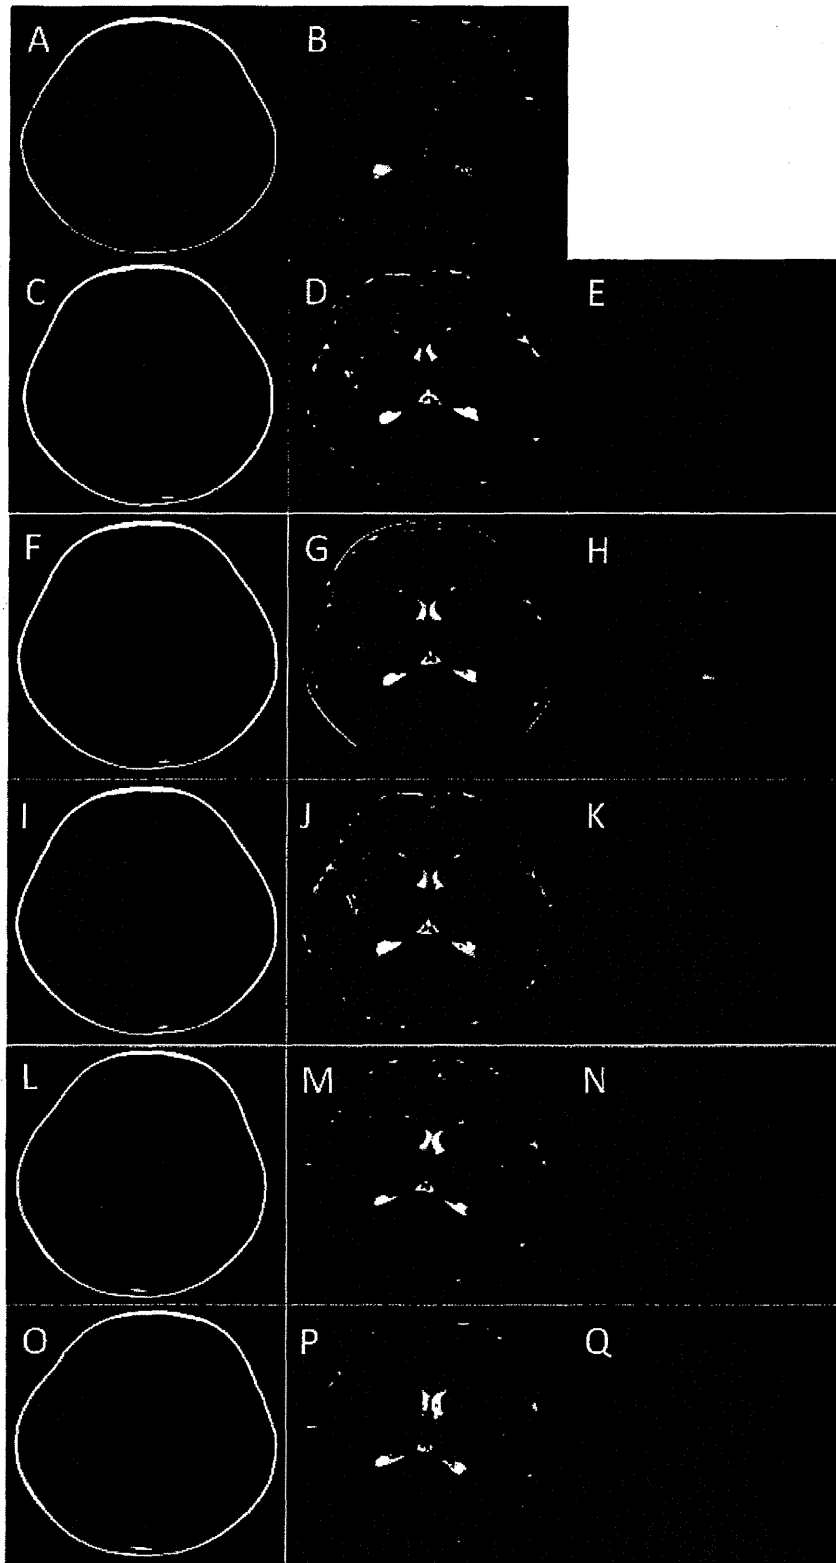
Magnetic resonance images of the first episode (A, B: on admission; C–E: 2 months after the admission), the second episode (F–H: on admission; I–K: on the 8th hospital day), and the third episode (L–N: on admission; O–Q: on the 6th hospital day). Diffusion-weighted image in the first episode on admission was not performed. Hyperintense signal in the splenial lesion of the corpus callosum (SCC) on T2-weighted image in the first episode (B), on T2-weighted and diffusion-weighted images in the second episode (G, H), and in the third episode (M, N) completely disappeared at 2 months after (D), 7 days after (J, K), and 5 days after (P, Q). Except for SCC lesions on diffuse-weighted and T2-weighted images, no other abnormal enhancements were observed, including on T1-weighted images.
